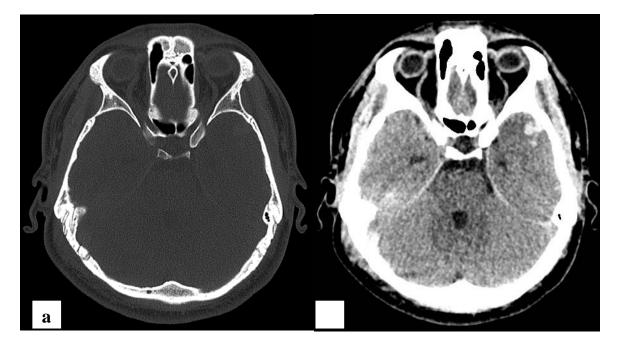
Axial plain CT brain of a 21-year old patient showing (a) bone window; no fracture and (b) brain window; intraparenchyma haemorrhage at the left temporal region.
